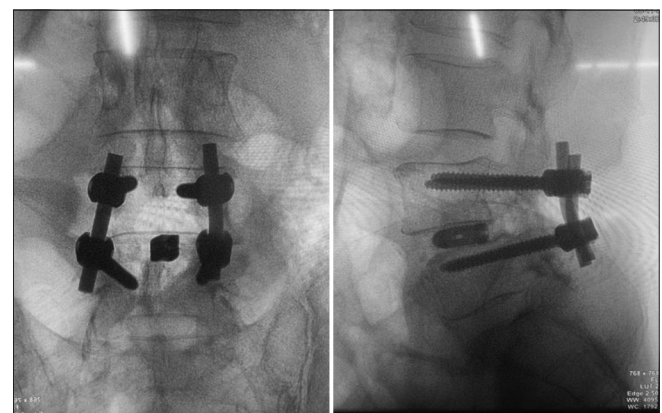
Sagittal X-ray anteroposterior/lateral view showing the transforaminal lumbar interbody fusion
